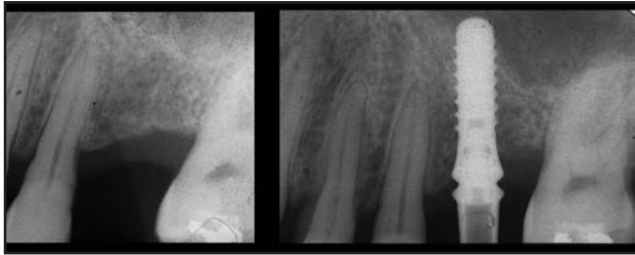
Periapical X-Rays of implant placed using BAOSFE technique, prior to surgery and 6 months post-surgery.
